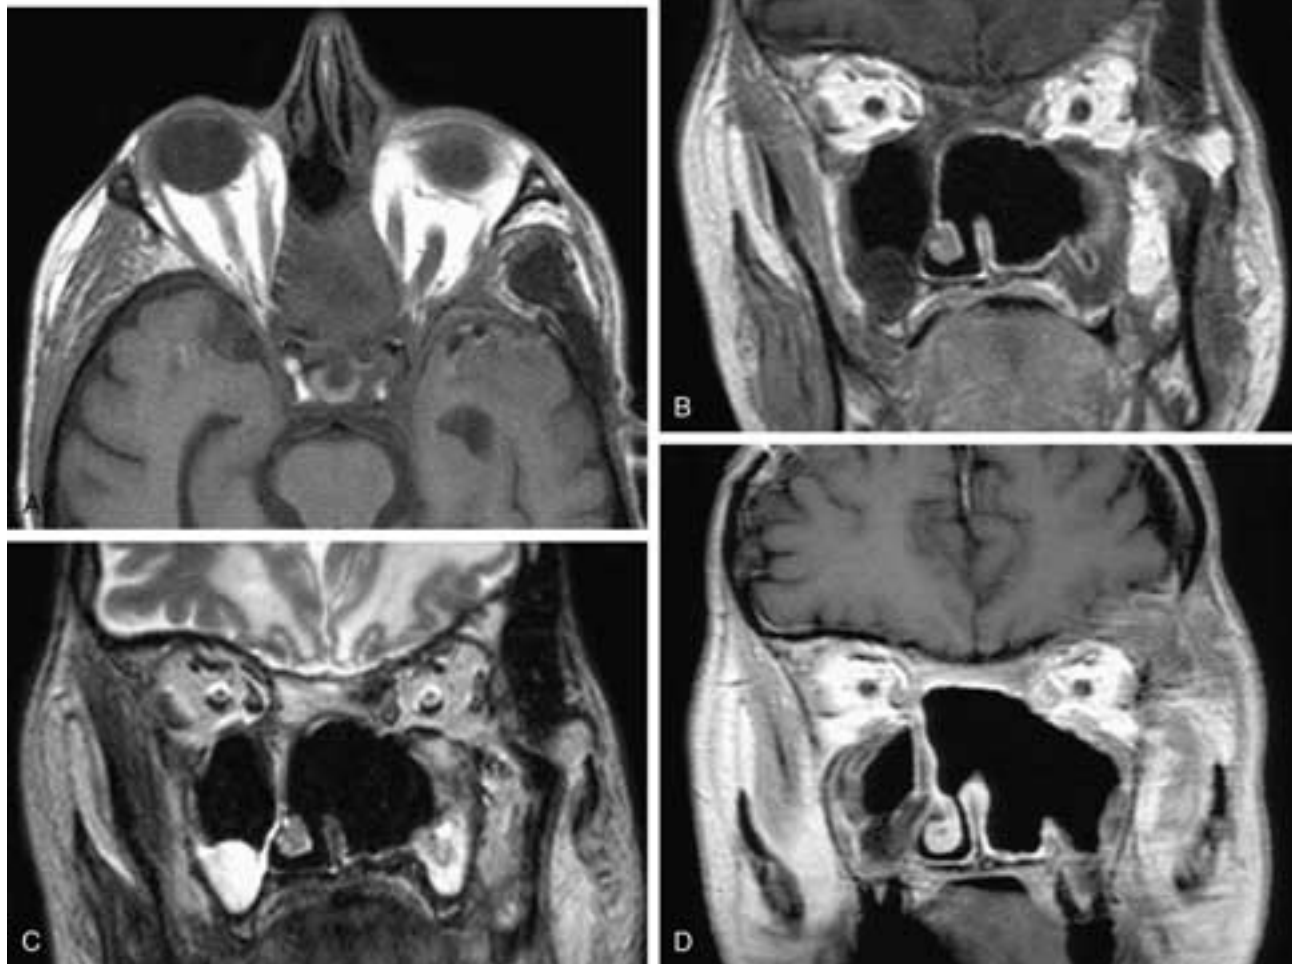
Axial T1-weighted (A) and coronal T1-weighted (B), T2-weighted (C), and T1-weighted, fat-suppressed, contrast-enhanced (D) MR images on a patient who has had a craniofacial procedure. In (A) a “pseudomass” is seen in the midline upper nasoethmoid region. This is the flap as it hangs down into the upper sinonasal cavity. This is confirmed on the coronal images, where smooth margins are seen along the intracranial, sinonasal, and orbital margins. Incidental inflammatory disease is present in the right maxillary sinus. This is the normal postoperative appearance of a patient who has had a craniofacial procedure.
